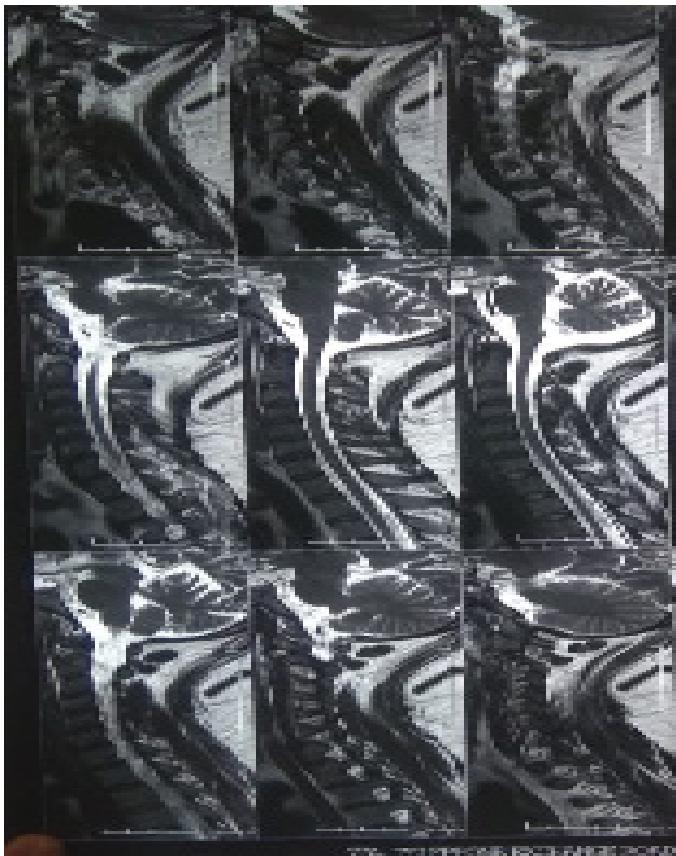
MRI cervicodorsal spine is normal.
